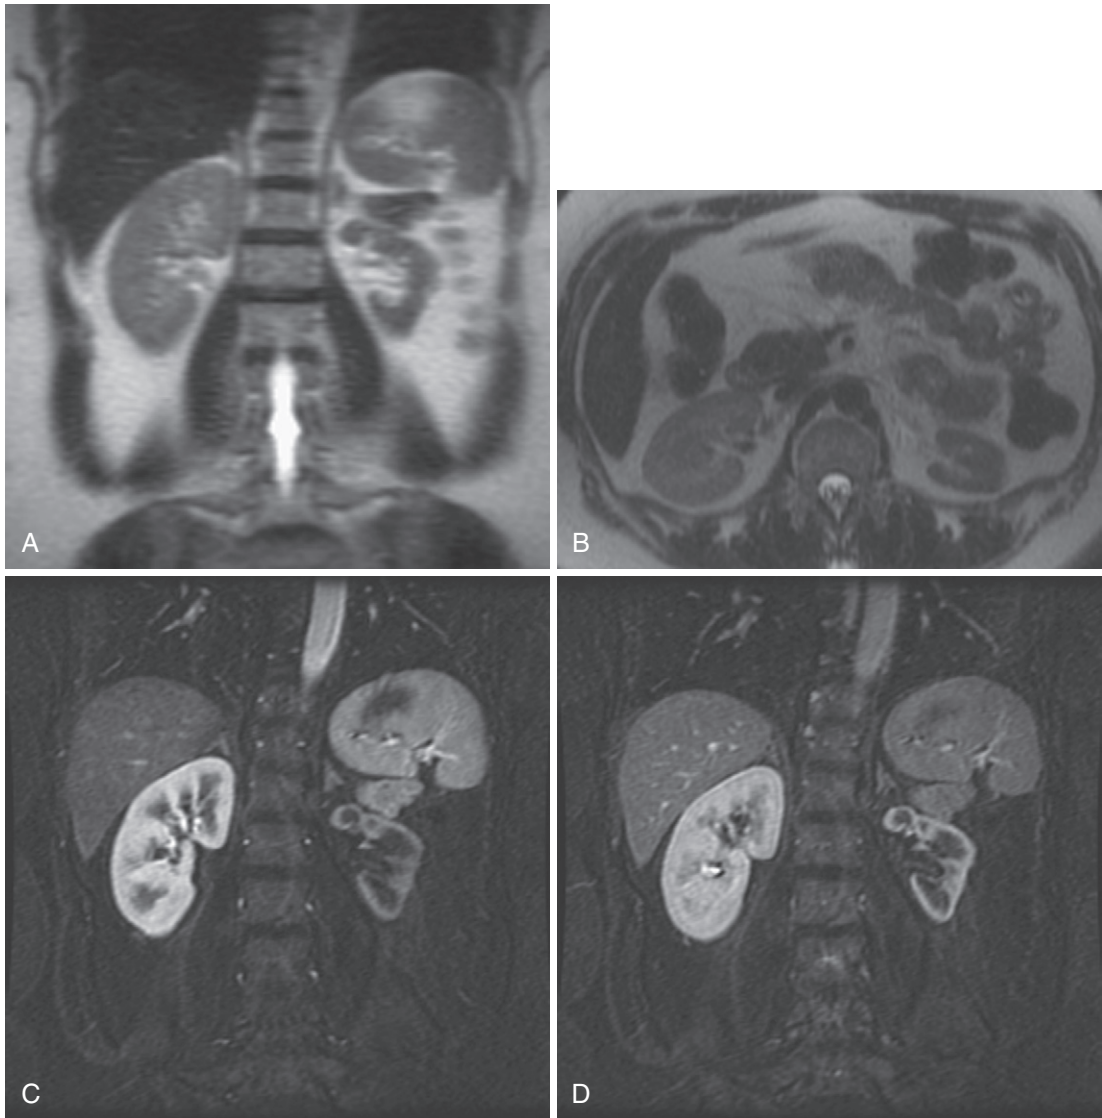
Renal artery stenosis. The coronal (A) and axial (B) T2-weighted images reveal marked asymmetrical left-sided renal atrophy and lack of corticomedullary differentiation. Early (C) and delayed (D) postcontrast coronal images show a corresponding delayed left-sided nephrographic phase compared with the normal right kidney.
